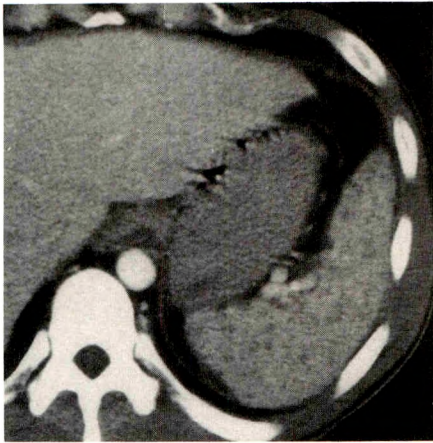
Abscess. Another manifestation of septic spleen is a myriad of tiny low-attenuation areas, as shown on this CT scan. In this immunocompromised patient, pattern of microabscesses suggests fungal infection. *Candida* was cultured from patient.
